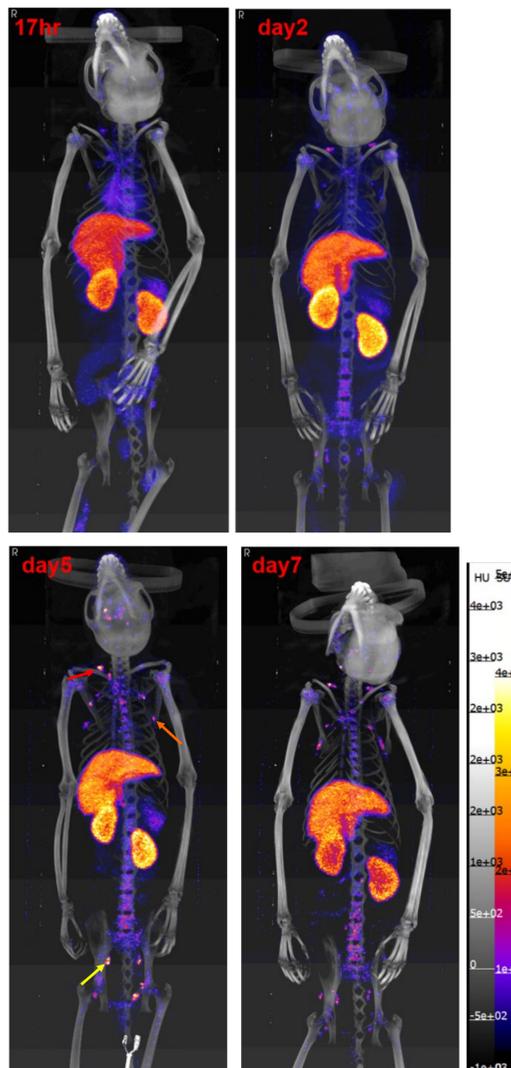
Full body PET/CT images of an NHP post injection of ⁸⁹Zr-Crefmirlimab berdoxam showing high uptake in the liver and kidneys with distinguished higher uptake in the renal cortex. A high uptake can be observed in the cervical, axillary, inguinal lymph nodes (red, orange, yellow arrows, respectively).
